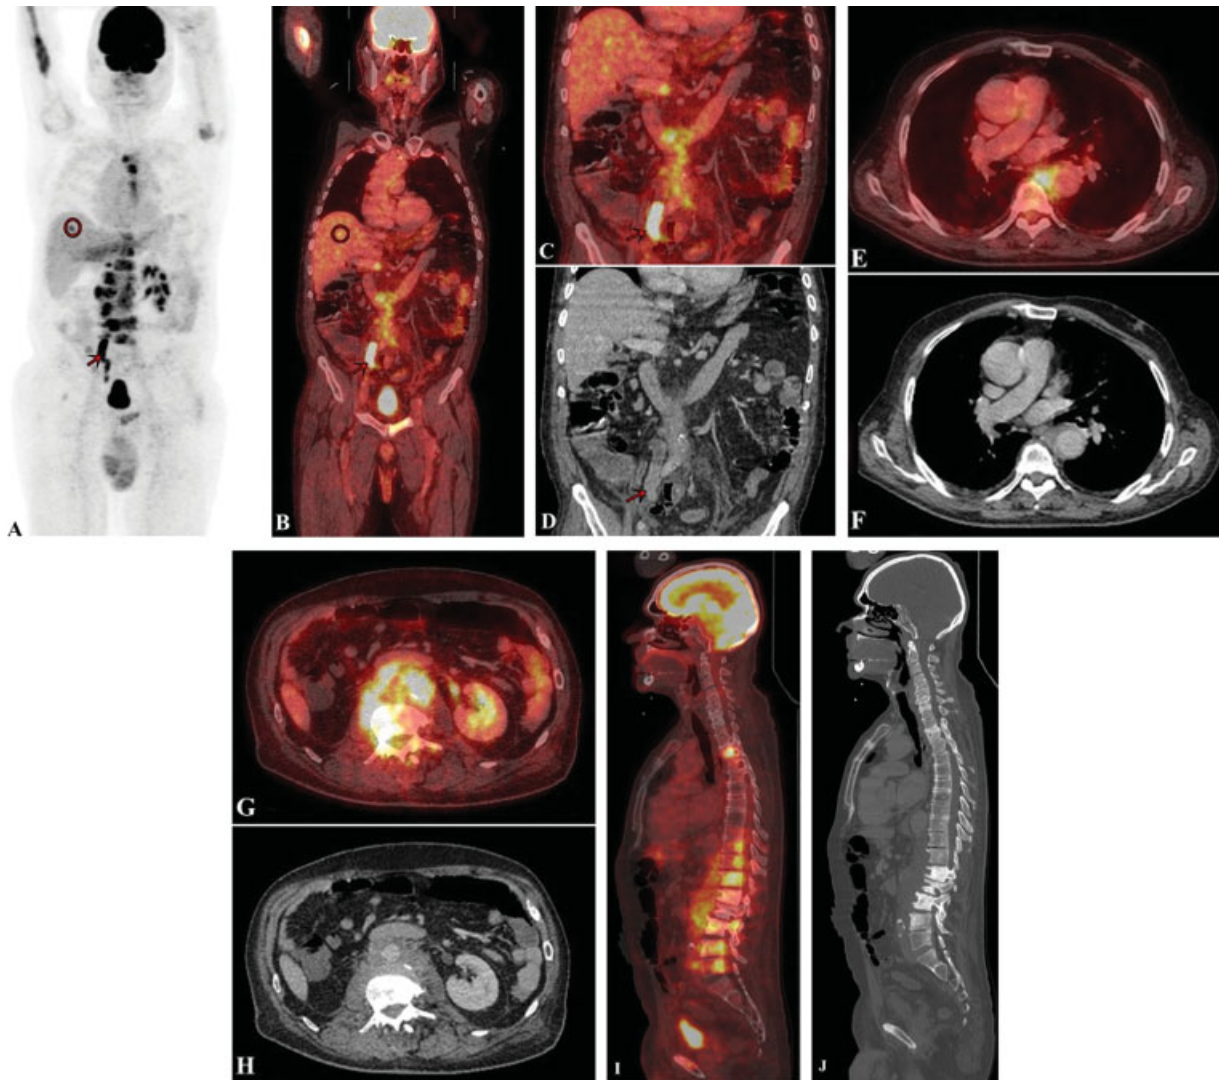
Maximum intensity projection and ¹⁸F-fluoro-2-deoxy-D-glucose positron emission tomography/computed tomography (¹⁸F FDG PET/CT) images (A and B) show increased FDG uptake in mediastinal, retroperitoneal lymph nodes, right ureter (red arrow), multiple skeleton lesions, and suspicion for malignancy focus in the liver (red circle). Coronal FDG PET/CT image (C) revealed an intense FDG uptake in the right ureteral stump corresponding to a solid soft-tissue formation in the lumen on the contrast-enhanced computed tomography (CECT) component (D), compatible with primary tumor. Axial FDG PET/CT (E and G) slices demonstrate enlarged and hypermetabolic lymph nodes in mediastinal and retroperitoneal region, which presented as an ill-defined infiltrative lymphadenopathy on the CECT images (F and H). PET/CT sagittal image (I) of multiple FDG-avid lesions in axial the skeleton, corresponding to osteosclerotic bone metastasis on the CT (J).
